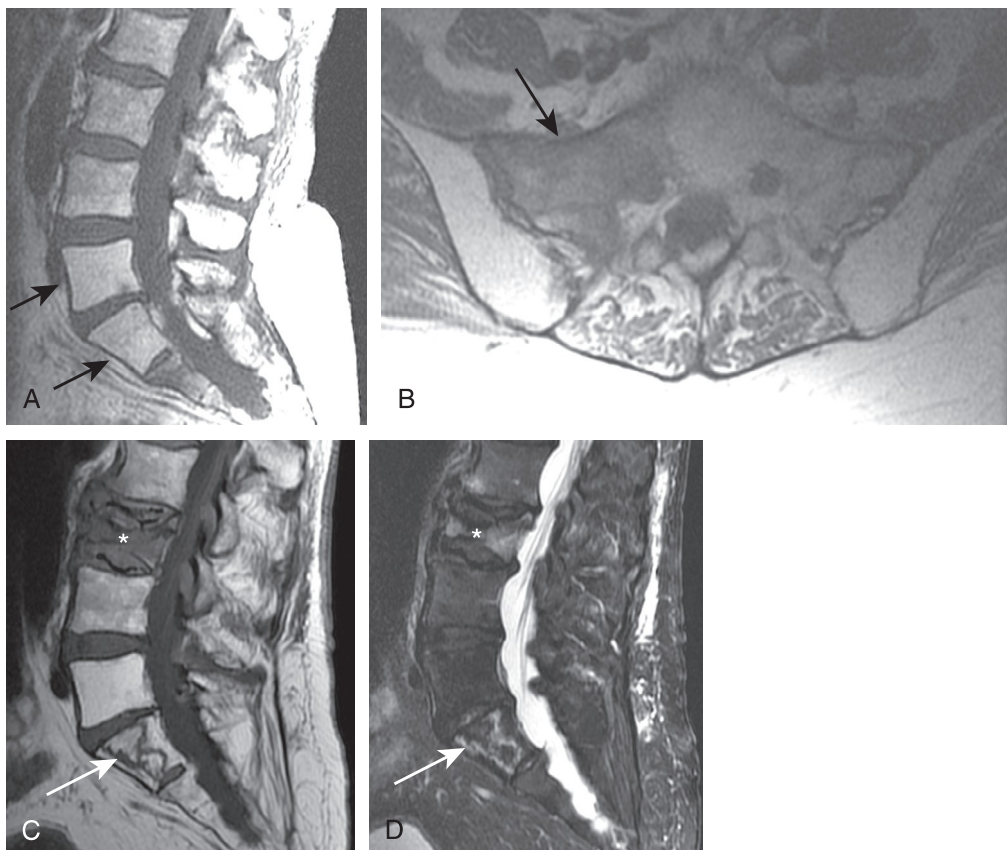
A 76-year-old female treated for cervical carcinoma with pelvic radiation. Sagittal T1-weighted imaging reveals hyperintense T1 marrow signal at L5 and S1 (*arrows*) consistent with complete fatty marrow replacement due to prior radiation (A). Axial T1-weighted image reveals a right sacral metastatic lesion (*arrow*) (B). Several years following a second round of pelvic radiation for the sacral metastasis, the patient suffered an acute L3 compression fracture (*). Sagittal T1- (C) and T2-weighted, fat-saturated (D) imaging also revealed a serpiginous region of T1 hypointense signal and T2 hyperintense signal within S1 (*arrow*), suggestive of osteoradionecrosis.
